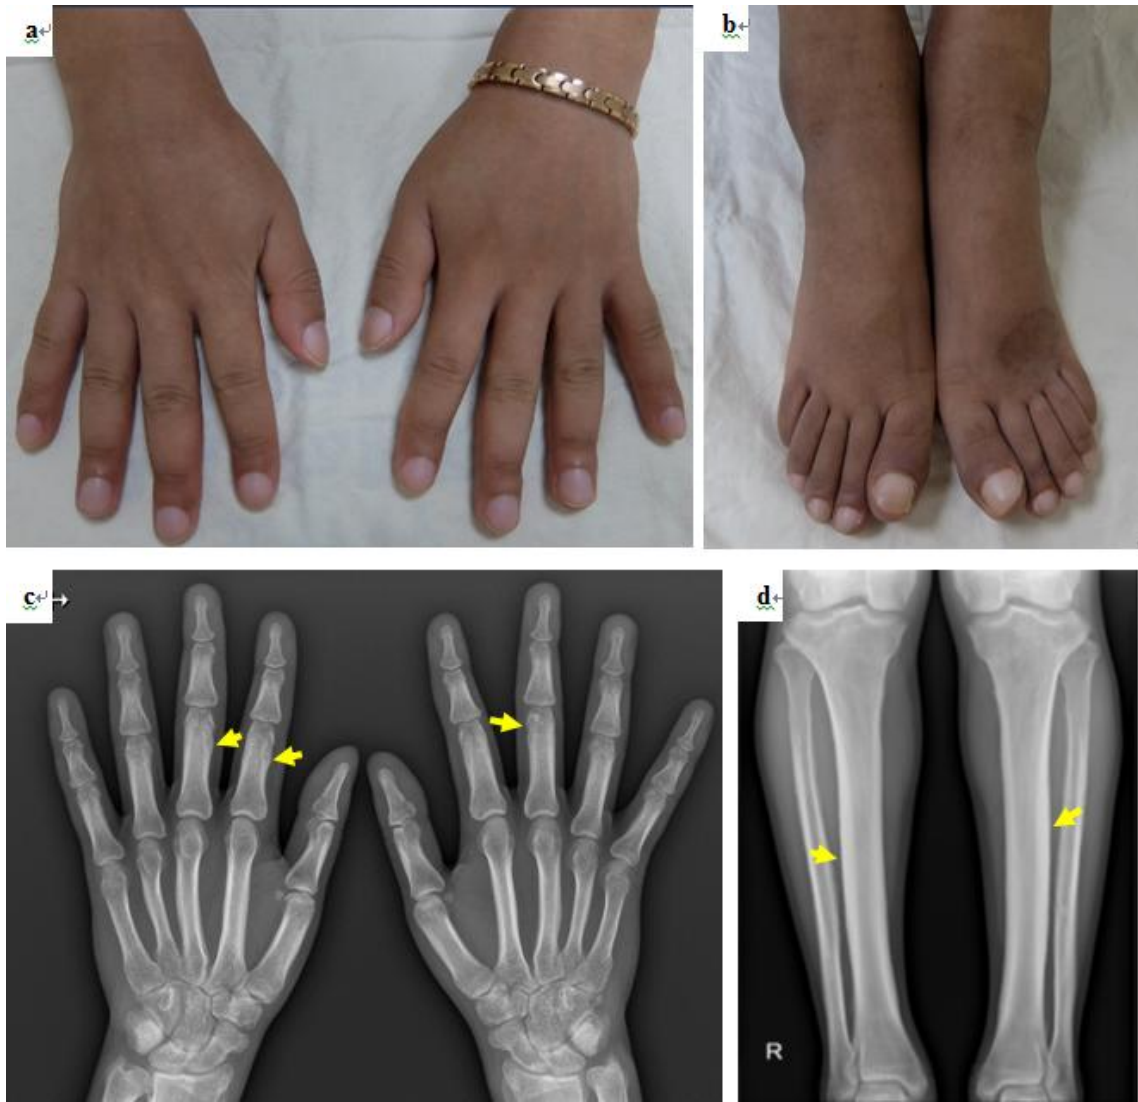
Clinical features of the patient with primary hypertrophic osteoarthropathy. The patient in case 5 suffered from clubbing of fingers and toes, as shown in [a, b]. About one year before hospital admission, he complained about the coarseness of his face. Hand and lower leg x-ray shows diffuse periosteal thickening along the tubular bones [c, d]. Furthermore, he also had chronic diarrhea and history of duodenal ulcer with active bleeding. Sanger sequencing showed compound heterozygous *SLCO2A1* mutations.
